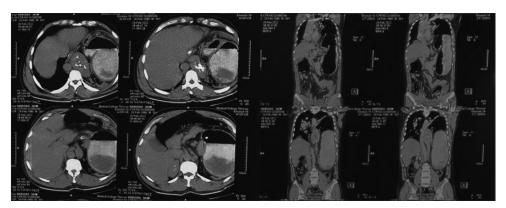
CT scan showing whole Left diaphragm elevated and thinned out with Spleen, transverse colon, stomach and small bowel loops in left thorax
